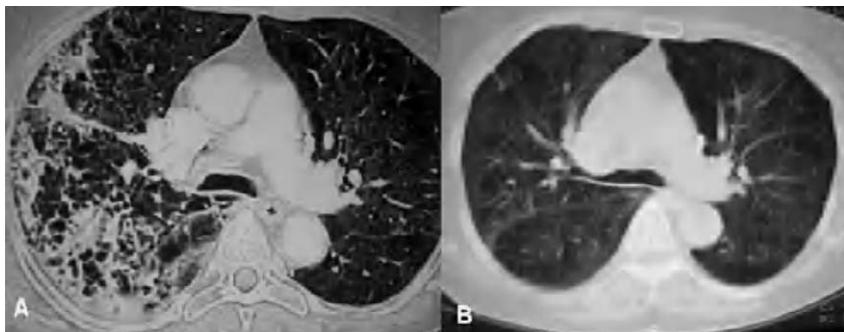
Computed tomography of the chest showing extensive alveolar infiltration with areas of necrosis and centrilobular emphysema in the right upper lobe. B: Computed tomography of the chest 45 days after admission.
